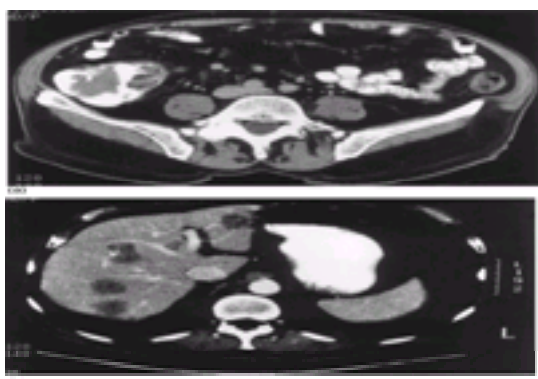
Abdominal computed tomogram revealing cecal cancer (a) with synchronous hepatic metastases (b).
